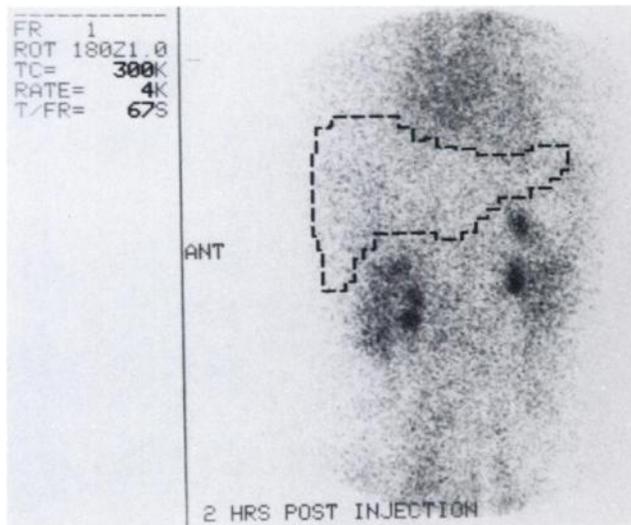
Technetium-99m-HIDA cholescintigram. The liver is not visualized and no radioactivity is excreted in the intestine after 2 hr.
